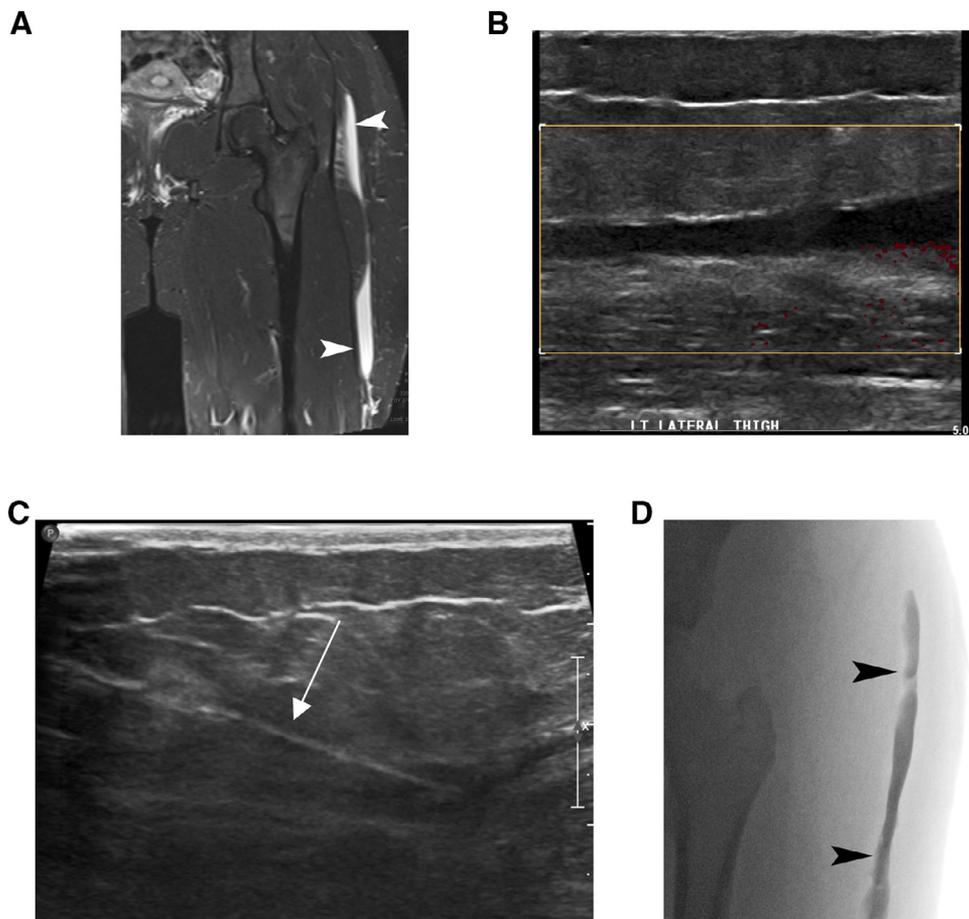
Adolescent female with history of traumatic injury to the left elbow, pelvis and leg (train vs pedestrian). Three months following injury and recovery, the patient presents for evaluation of fluctuance along the lateral aspect of the left thigh. Coronal T2W MR image (A) demonstrates an ellipsoid T2 hyperintense fluid collection at the myofascial junction between the vastus lateralis and subcutaneous fat compatible with Morel-Lavallee Lesion. Under ultrasound guidance (B & C), the anechoic, avascular collection (asterisks) was accessed with a needle and drain was placed (arrow). Contrast was injected and a single fluoroscopic image (D) was obtained to document placement and extent of collection. The patient was then treated with a cycle of 3 doxycycline treatments (100 mg/treatment). In this patient, fluid recurred 3 months post-treatment. The lesion eventually required capsulectomy for definitive treatment.
